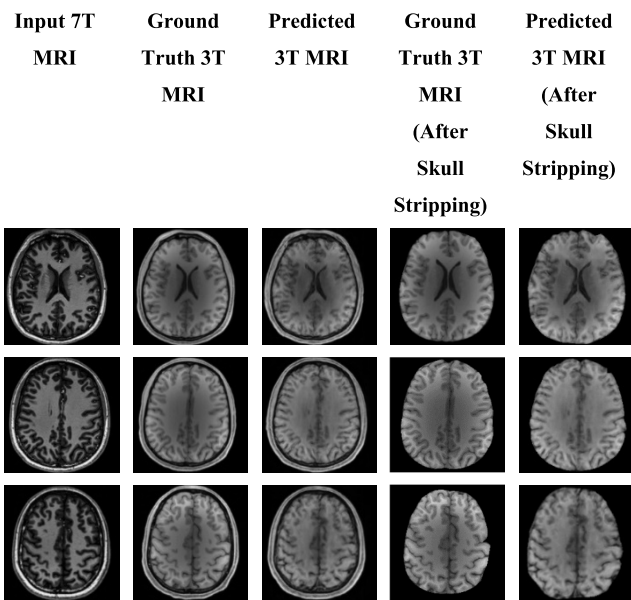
Predicted results by the best CycleGAN model for 7T to 3T MRI translation (before and after skull stripping).
